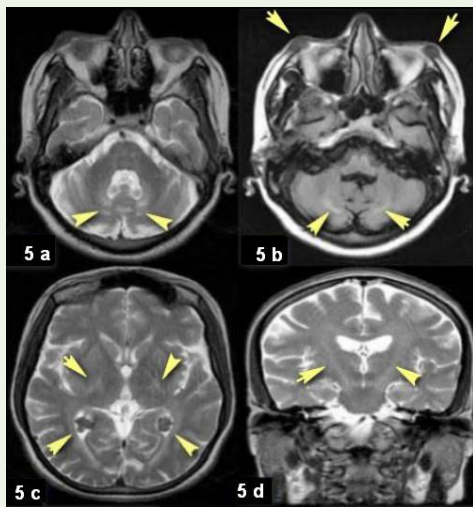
a-b axial T2wMRI and FLAIR sequence of Brain of Case 2 showing hyperintensity of dentate nuclei with foliar prominence of cerebellum (arrow head), c- axial T2 wMRI of Brain showing choroid plexus xanthogranuloma (arrow head), d-coronal T2 wMRI of Brain showing pyramidal tract hyperintensity (arrow head).
